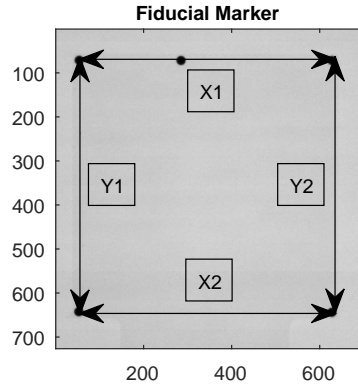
X-ray image of frame containing five fiducial markers on a  $8.4 \times 8.4$  cm square. Pixel spacing at the frame position is given by the number of pixels between markers divided by physical distance.
